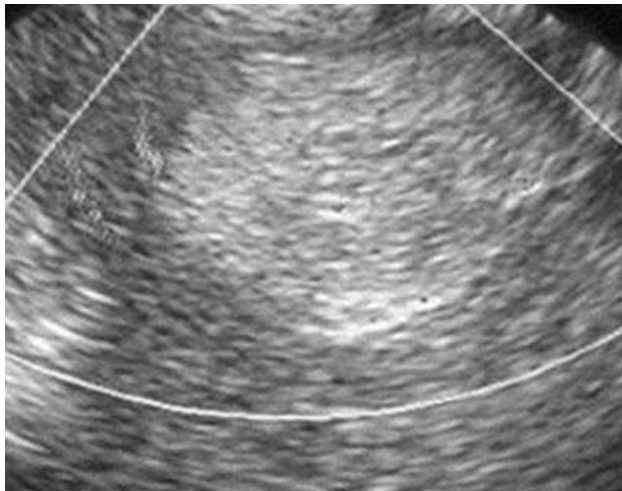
Ultra sound images axial and sagittal views showing large solitary hyper echoic mass lesion encased by hypo echoic rim noted in the anterior wall of uterus. No significant vascularity noted on color Doppler.
